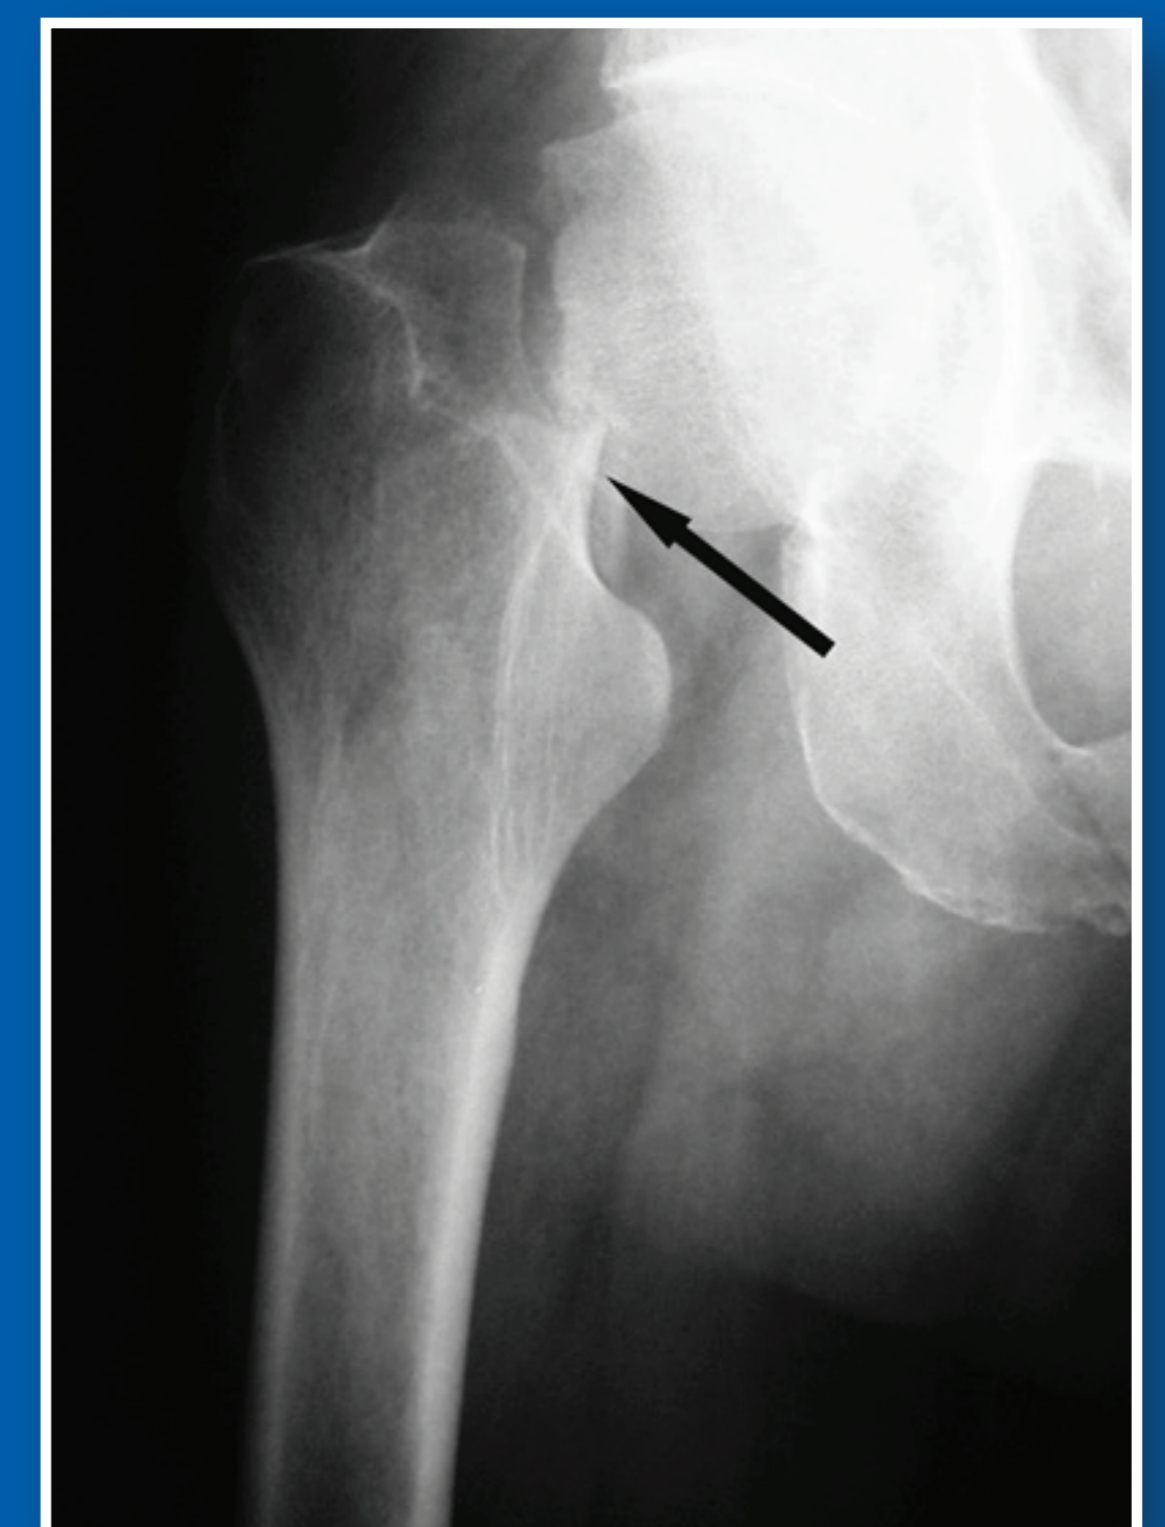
Anteroposterior (AP) radiograph demonstrating a fracture of the right hip.
